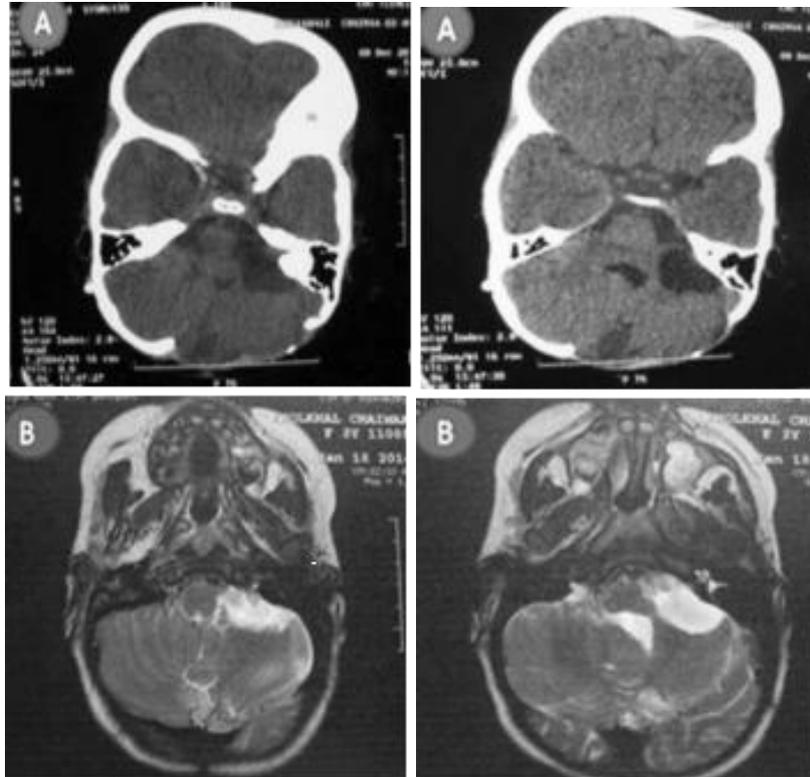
Postoperative brain CT scan showing complete excision of the dermoid cyst via a midline suboccipital approach, and the cerebellopontine angle (CPA) arachnoid cyst, which has not yet been operated on.
